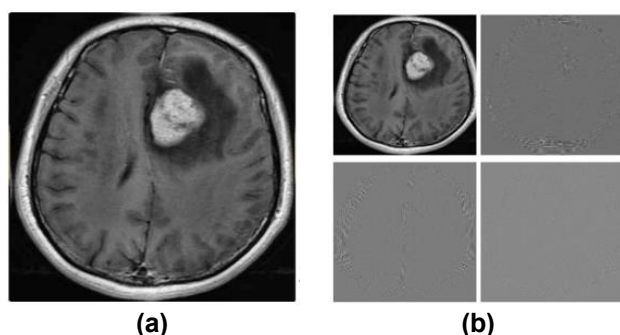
One-level 2D-DWT decomposition of Brain Tumor MRI (LL, LH, HL, HH) (a) Original Image (224,224,3), (b) One-Level 2D-DWT (112,112).
